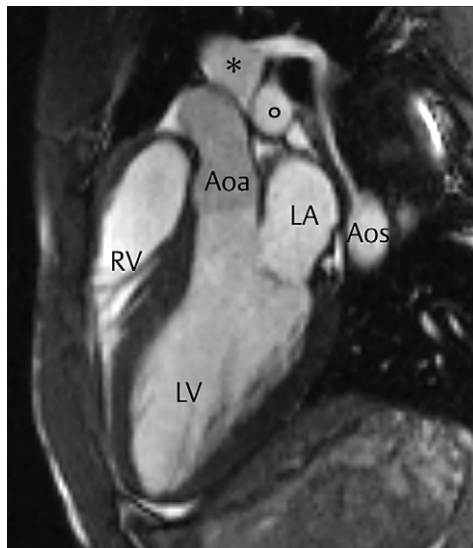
MRI of the heart showing the left ventricular outflow tract
